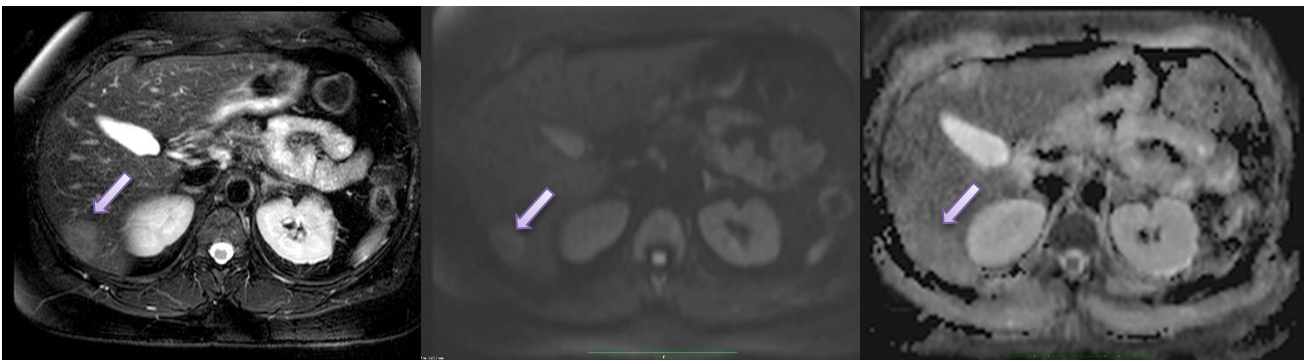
Diffusion-weighted MRI in a liver with an IHCA: (A) Fat-suppressed T2-weighted fast spin echo image shows a HCA located in the VI segment that is hyperintense to the liver; (B) in DW MRI with $b = 700 \text{ sec/mm}^2$, the lesion is slightly hyperintense compared with the background liver; (C) in the ADC map, the lesion has a similar signal to the one presented in the liver.
